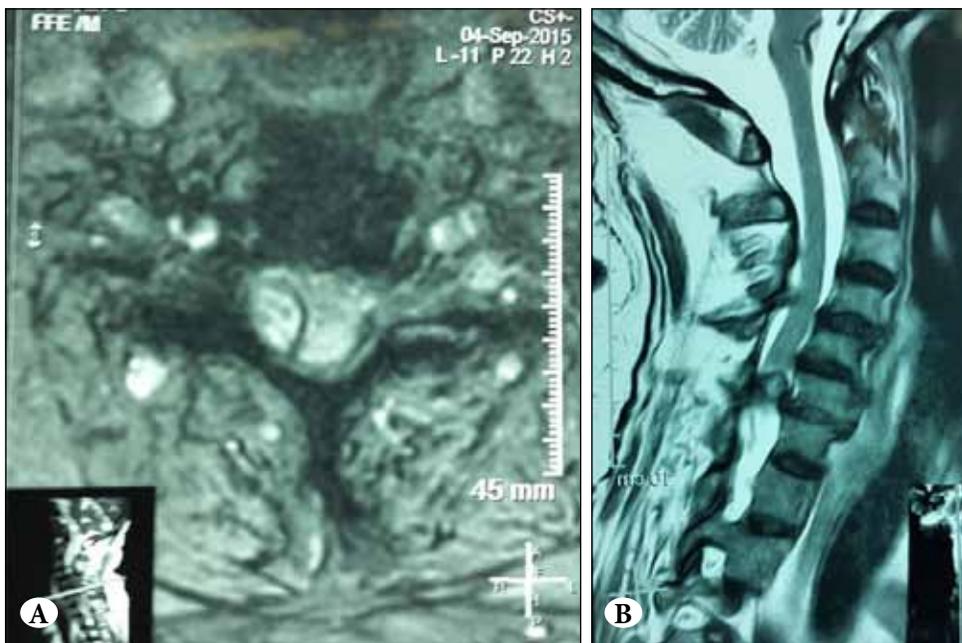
(A) Axial T2 weighted MRI showing a hyperintense mass on the right side (B) T2-weighted sagittal paramedian MRI showing the same lesion occupying almost the whole canal's anteroposterior diameter.
